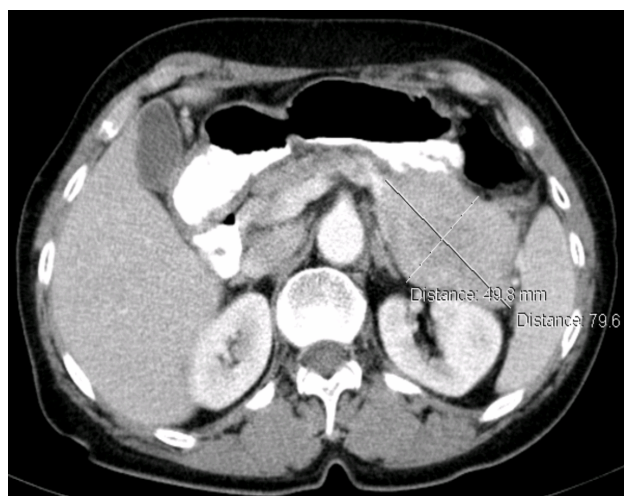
CT scan image of the abdomen, highlighting at pancreas tail the presence of a 79.6/49.8 mm tumor, with a relatively clear contour, a discrete heterogeneous structure, reaching the spleen hilum and covering the anterior side of the left kidney.
